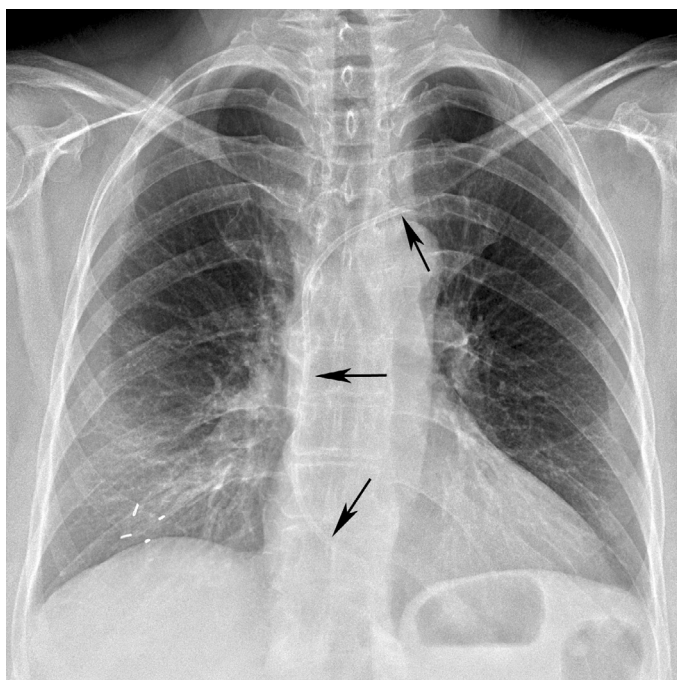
■ Posteroanterior (PA) upright chest x-ray. Retained portacath fragment (*arrows*) within left brachiocephalic vein, superior vena cava, and right atrium is the result of shearing the catheter.
